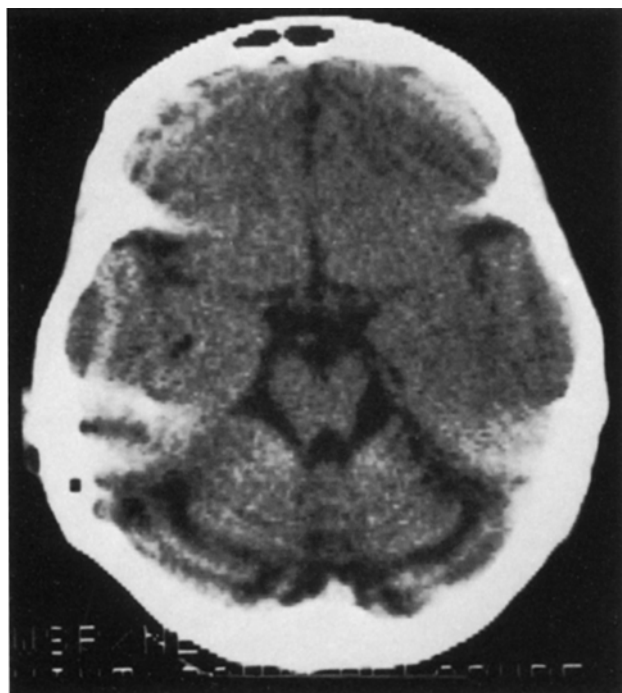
CT scan demonstrating cortical cerebellar atrophy and dilatation of basal cisterns
